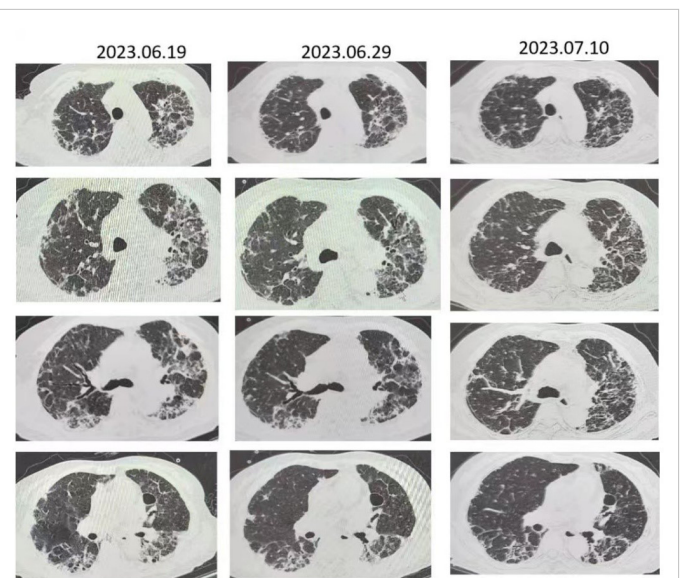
Chest CT at different points in time. The lung lesions shown by chest CT had gradually resorbed compared to previous images.
